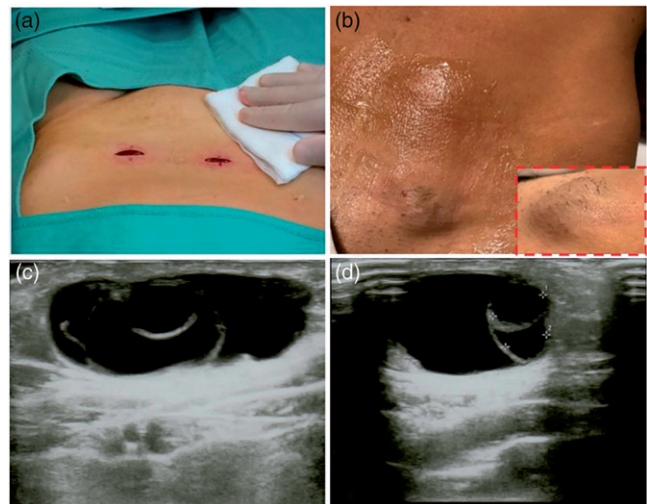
Surgical techniques of (A) heterotopic transplantation in two pockets created in the abdominal wall above the rectus muscle. (B) Bulge observed in the transplantation areas sixteen weeks after ovarian tissue grafting. (C) Transabdominal ultrasound showing numerous follicles in the heterotopic site twelve weeks after second transplantation. (D) Detail of transabdominal ultrasound showing three 17, 6 and 5-mm diameter follicles in the heterotopic site.
